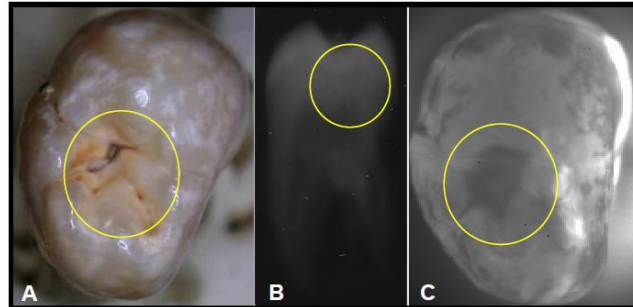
Example of NIR transillumination image of a dentine occlusal demineralisation. (A) Reflected white light image of molar with a large lesion (yellow circle) in the central fissure, (B) Radiograph, (C) NIR transillumination image[65].
